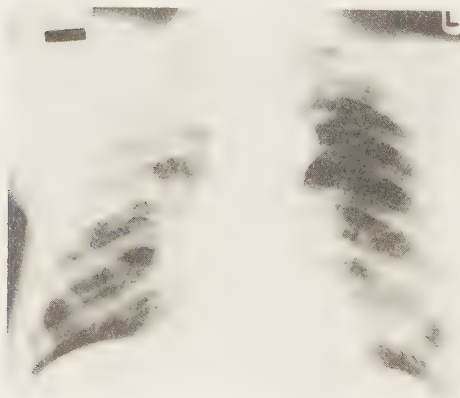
Chest radiograph of patient 1, showing right upper-lobe pneumonia.
